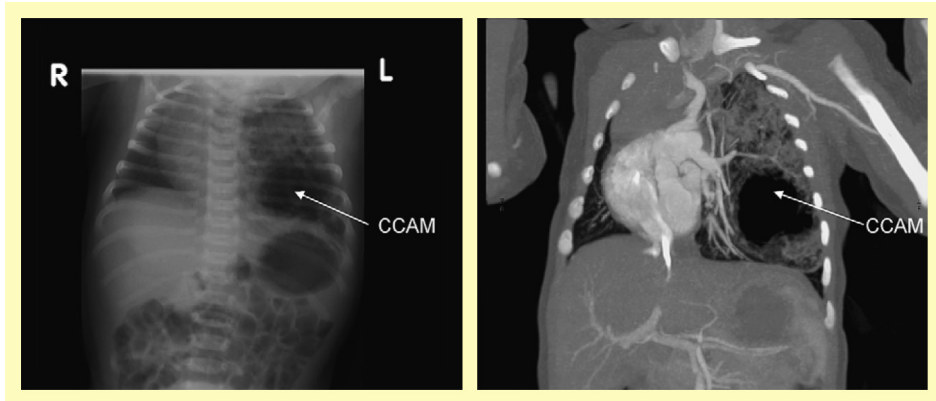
Chest radiograph and CT Scan showing right lower lobe CCAM.
